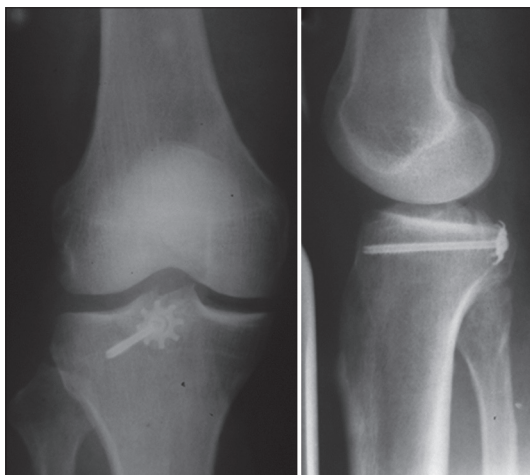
Anteroposterior and lateral x-rays of knee joint showing avulsion fracture of posterior cruciate ligament fixed with stellate steel plate
